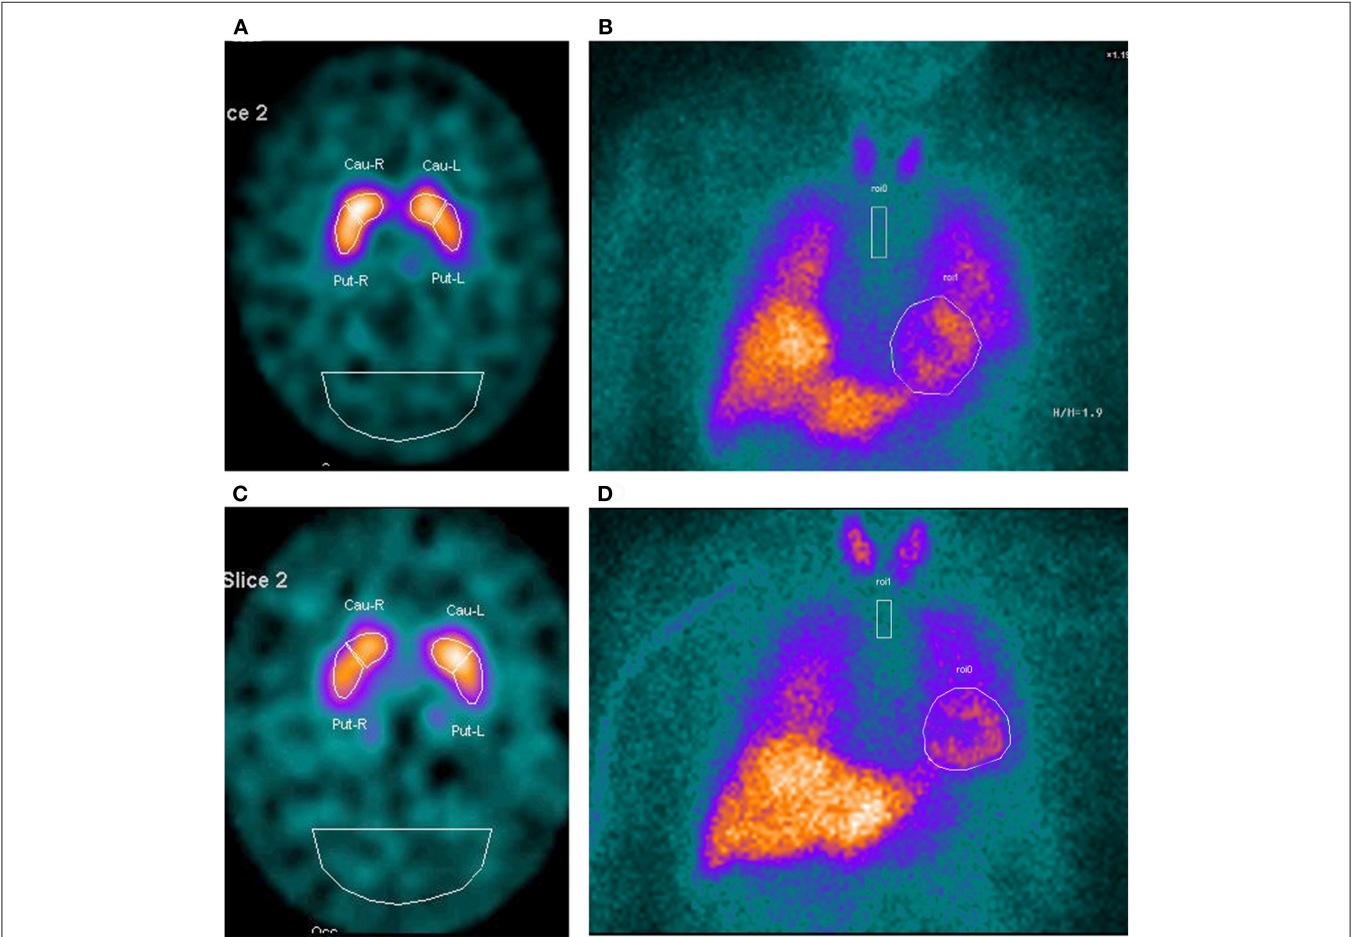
DAT-SPECT imaging and cardiac MIBG scintigraphy in a patient with ET^{RBD+} (A,B) and in a patient with ET^{RBD-} (C,D). The images show in both patients a normal uptake of the tracers.
